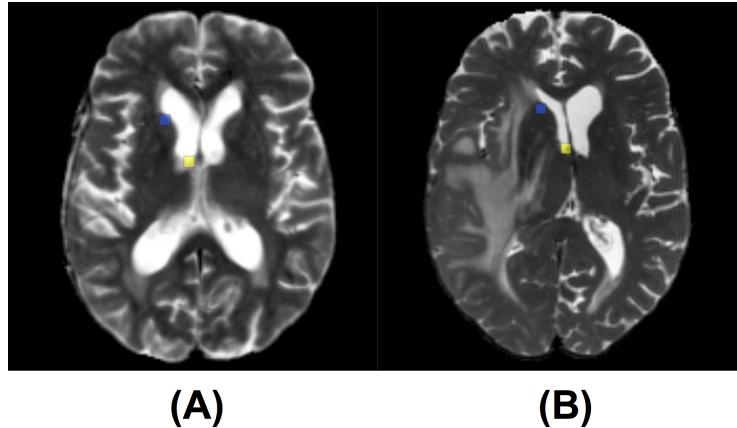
Example of annotated landmarks on Test Set. Subfigures A and B correspond to post and pre-operative MRI acquisitions of the same patient. The corresponding landmarks are visualized with the same colors.
